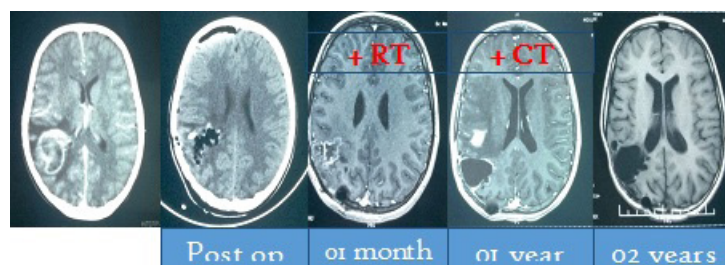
Axial Brain CT Scan images of a 10-year-old patient operated in 2012 for parieto-occipital glioblastoma Parietal glioblastoma with spontaneously heterogeneous density and signal contrast uptake with significant perilesional edem
